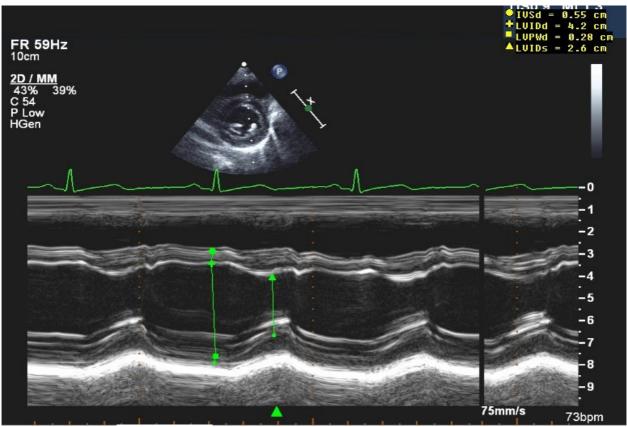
follow up echocardiography showed normal ventricular contraction
